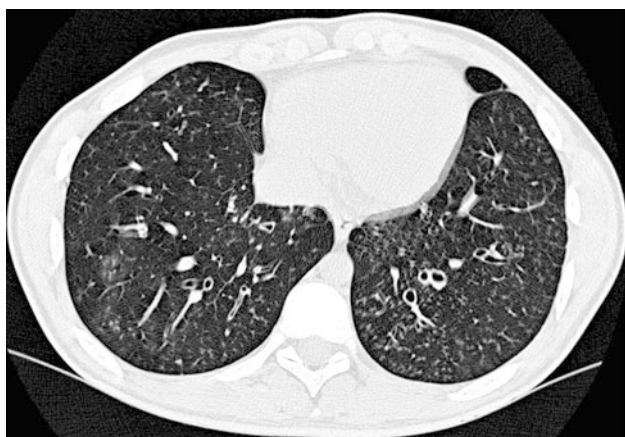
A 15-year-old girl with cystic fibrosis. HRCT detects cylindrical bronchiectasis with bronchial wall thickening (a). Expiratory air-trapping reflects the presence of small airways disease (b)
